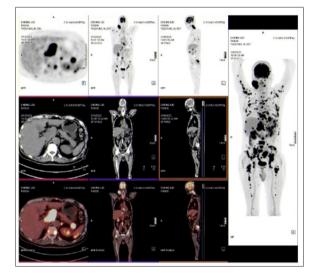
Second PET-CT showing massive newly established metastases in liver, lung, many bone and muscle locations
